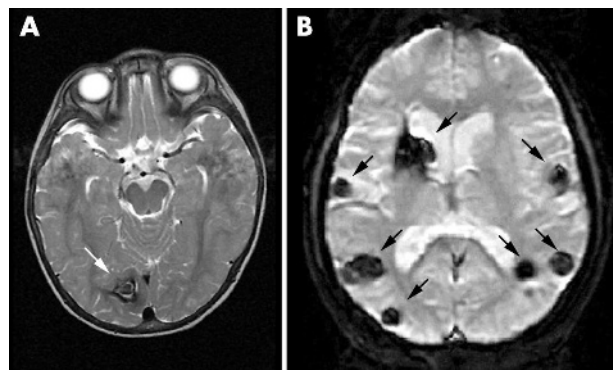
(A) Axial T2 weighted magnetic resonance imaging sequence; solitary lesion (white arrow) in the right occipital lobe in a 3 year old boy. (B) Axial T2 weighted gradient echo sequence; multiple supratentorial cerebral cavernous malformations (black arrows) in a young adult.
